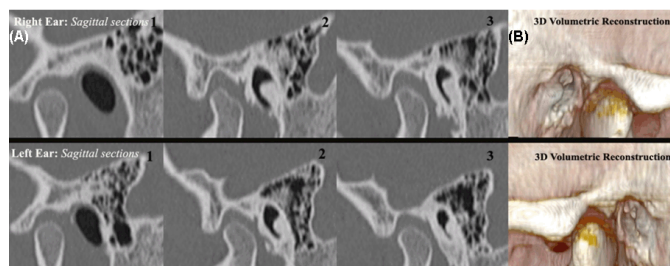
(A) High resolution computed tomography image showing multiple sagittal sections through the external auditory canals showing bony outgrowth, (B) 3D volumetric reconstruction.
